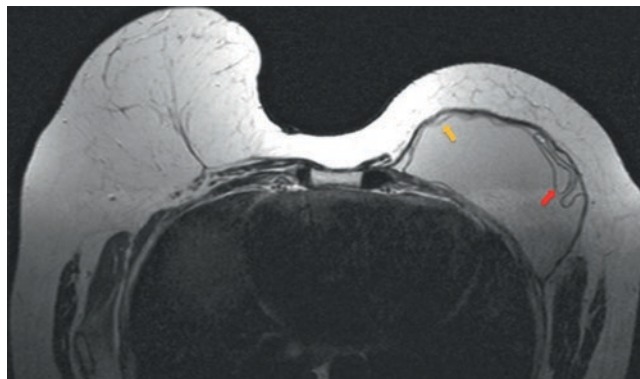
Breast MRI with T2 sequence without fat suppression showing an intracapsular rupture: Linguini sign (red arrow) and a subcapsular line (yellow arrow)
